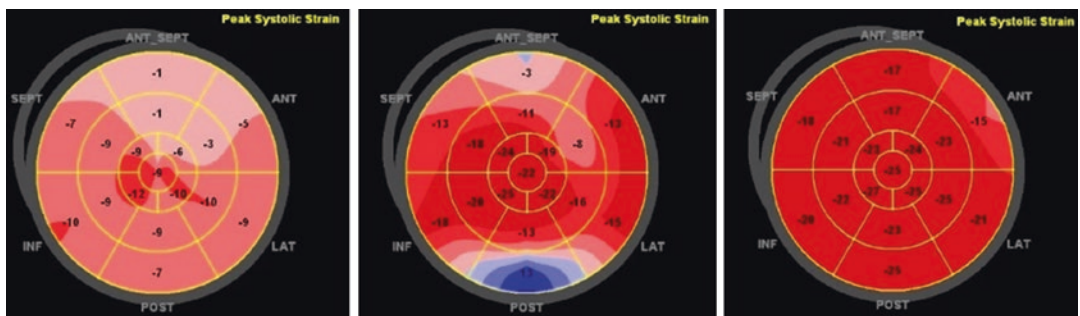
“Bull’s eye pattern” of ventricular wall movement by cardiac ultrasound spot tracer on days 1, 3, and 8 after admission. The lighter the red color is, the weaker the chamber wall movement and the darker the chamber wall movement. Blue indicates that the ventricle wall is moving in the opposite direction. Dynamic echocardiographic
